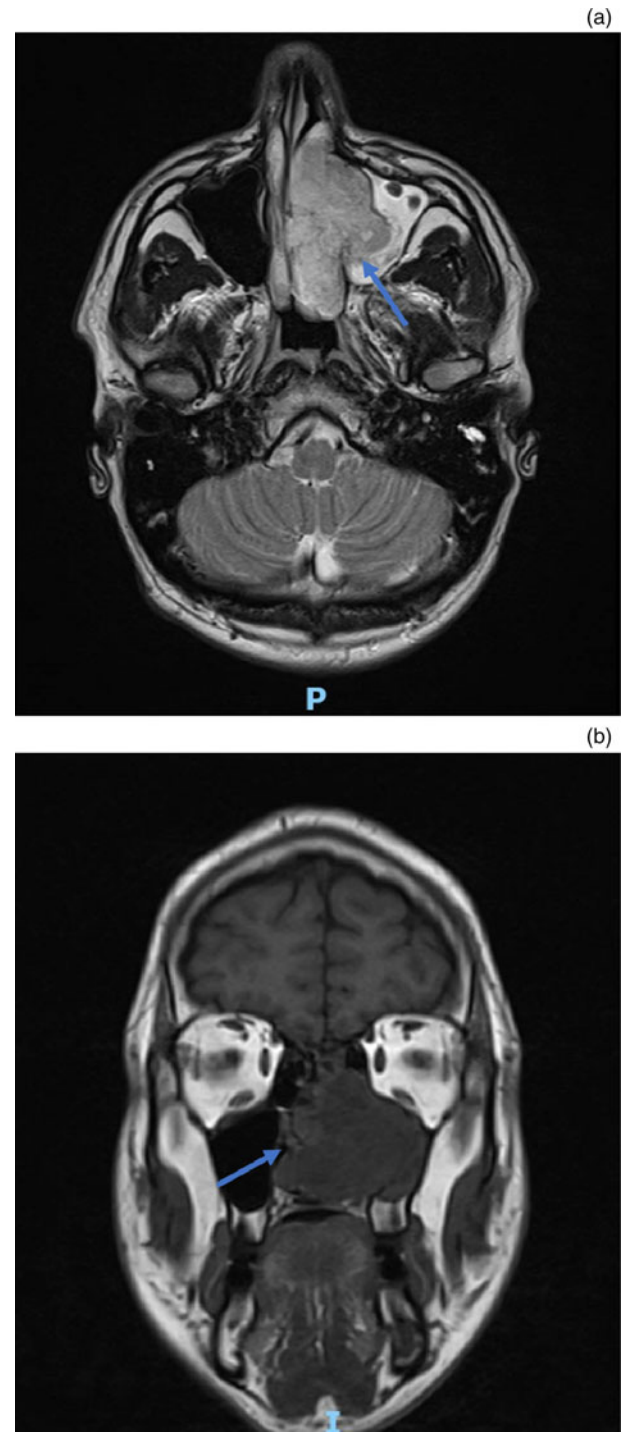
Axial T2-weighted (a) and coronal T1-weighted (b) magnetic resonance imaging scans, showing a left-sided nasal cavity mass extending into the maxillary sinus and ethmoid cells (arrows). The tumour has contact with the orbital floor and left lamina papyracea without breach of the periorbita; it extends into the left posterior choana and sphenopalatine foramen, and anteriorly into the vestibule. P = posterior; I = inferior
